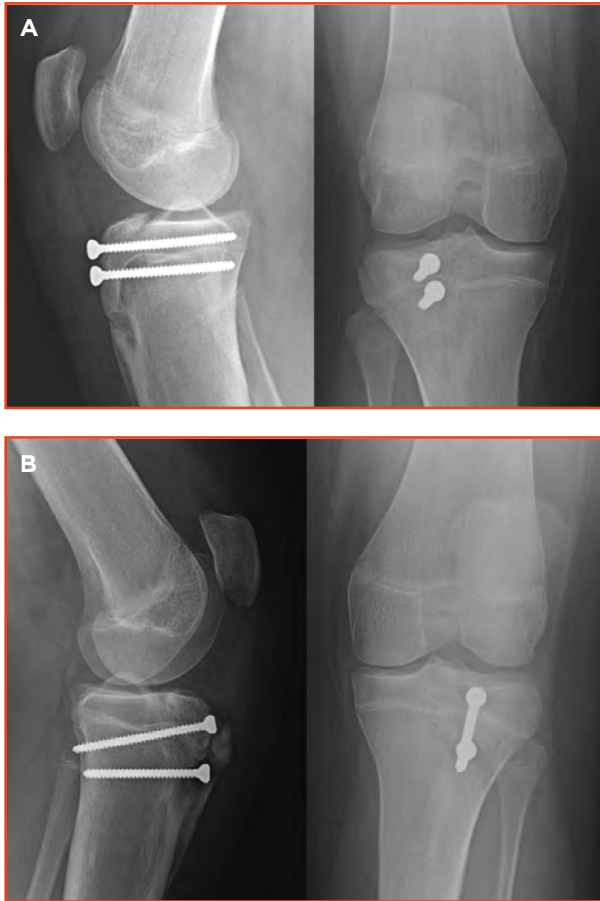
Radiographs of A) right and B) left knees at 14-weeks postoperatively, showing healed fractures.
